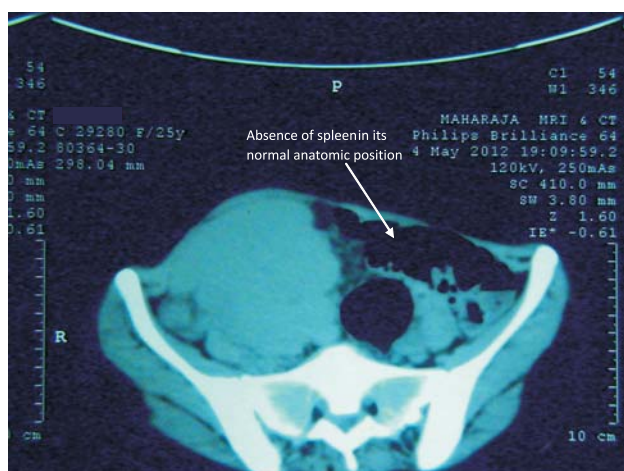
CT scan abdomen showing absence of spleen in its normal anatomic position.
